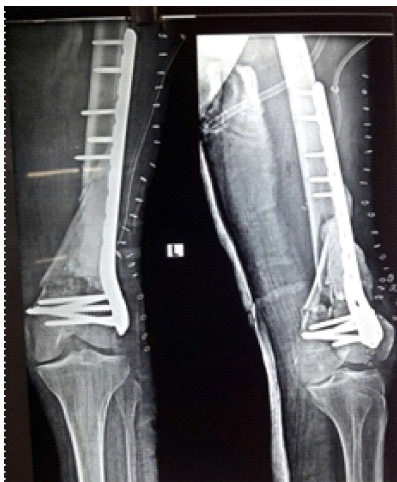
post operative x-ray with cement spacer
